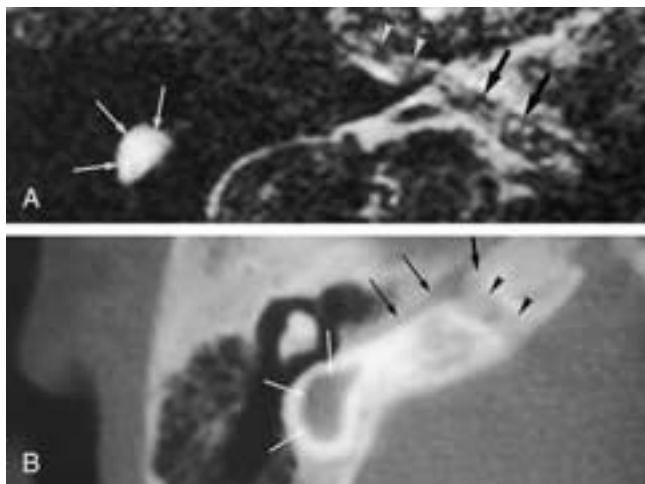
Common cavity type of cochlear-vestibular malformation. A, Axial 0.7 mm thick gradient-echo image through the left inner ear. Only a single fluid-filled cavity (*long white arrows*) can be seen in the right inner ear. The neurovascular bundle, however, is present in the cerebellopontine angle (*large black arrows*) and the IAC (*white arrowheads*). B, Axial CT image through the right inner ear. The single inner ear cavity can again be seen (*long white arrows*). The IAC (*black arrowheads*) and the tympanic segment of the facial nerve canal (*long black arrows*) can be seen. No cochlear structure is visible at the site anterior to the IAC, the site where the cochlea is normally situated (*small black arrow*).
